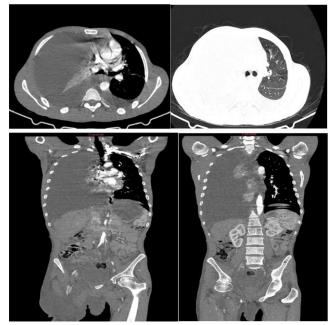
CT scan showing supra- and subaponeurotic tissue infiltration with intra- and subperitoneal extension, pleural localization and worsening bone involvement
